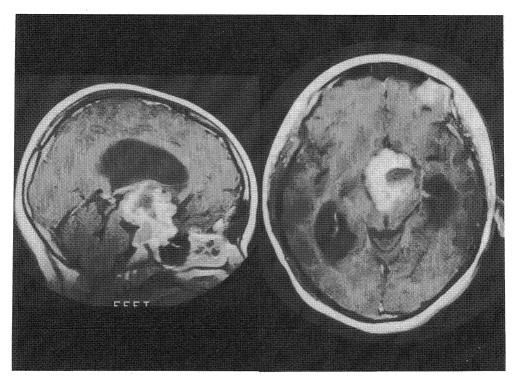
MRI scan demonstrating a large tumor extending to third venricle accompanying hydrocephalus (enhanced by Gd-DTPA).
